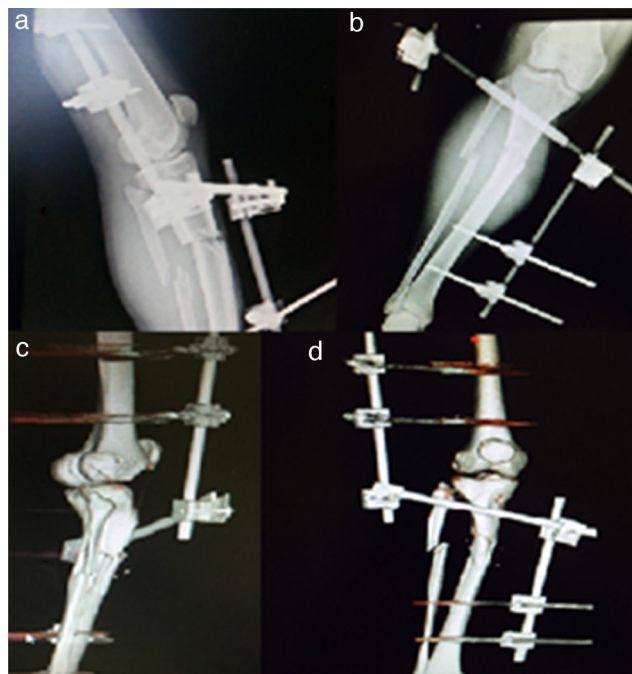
(a) Plain lateral view radiograph; (b) plain anteroposterior radiography; (c) lateral view 3D reconstruction CT scan; (d) anteroposterior 3D reconstruction CT scan.
